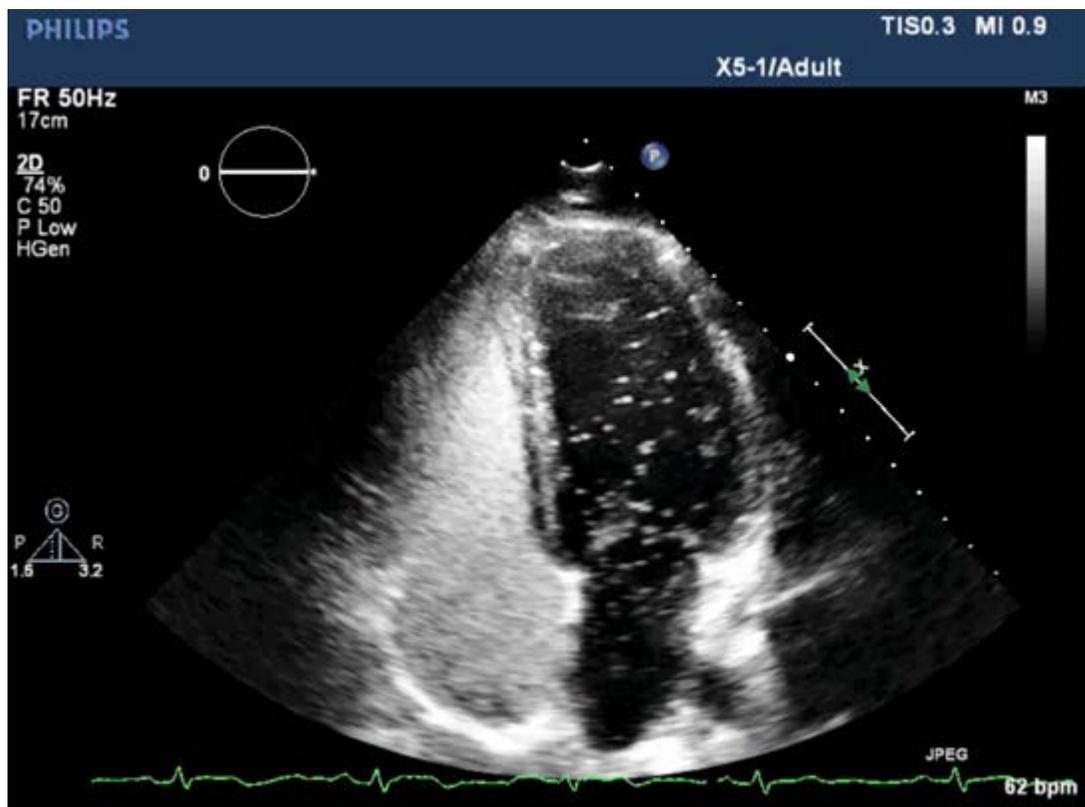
Bubbles in the Right and Left Heart detected with Ultrasound
